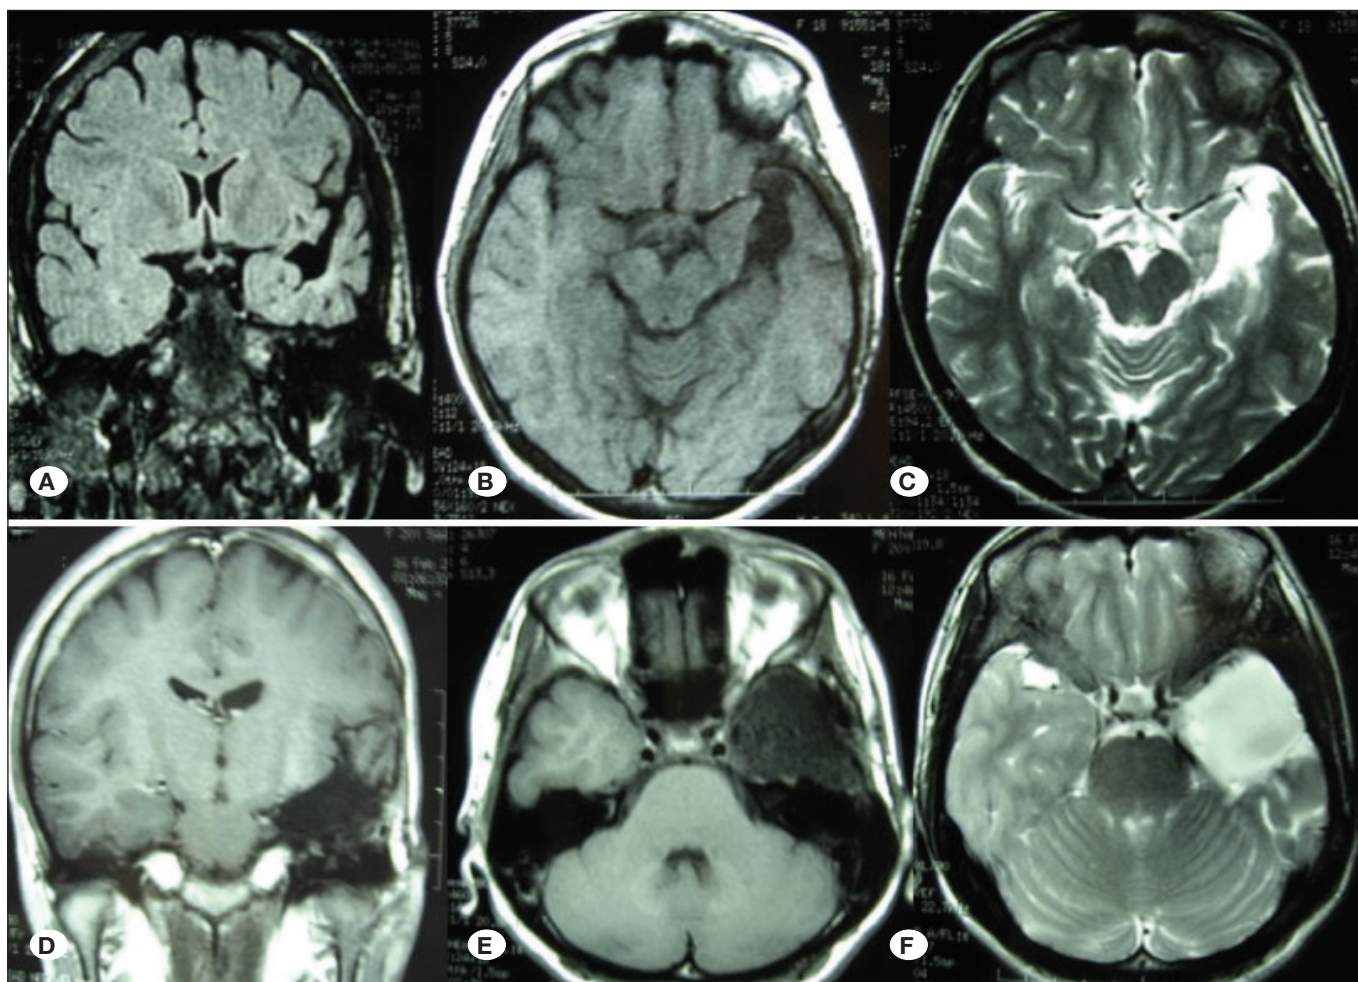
A-C) Preoperative brain magnetic resonance imaging (MRI) sections (A: T1W coronal, B: T1W axial, C: T2W axial) of patient #3; D-F) Postoperative MRI sections (D: T1W coronal, E: T1W axial, F: T2W axial) of patient #3.
